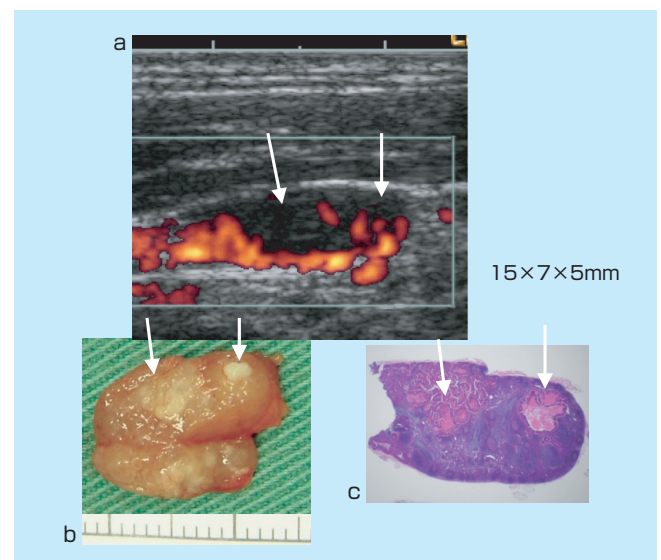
Small metastatic lesions detected by ultrasonography In this lymph node, which was $15 \times 7 \times 5$ mm, defects in blood flow were noted by power Doppler US (arrows) (a). Small metastatic lesions were found at the sites of blood flow defects (b, c).
